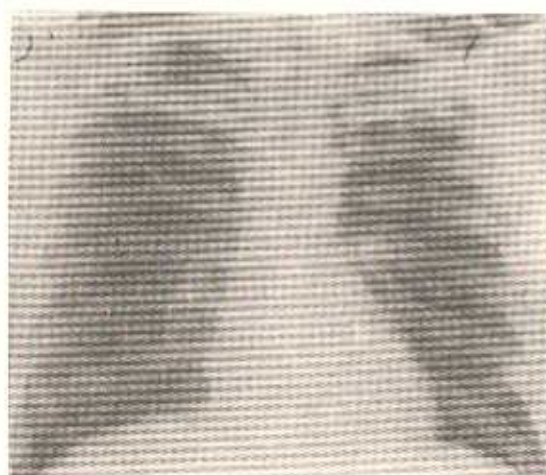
X-Ray Chest (PA View) of IS (Sl. No. 8) at Delhi
